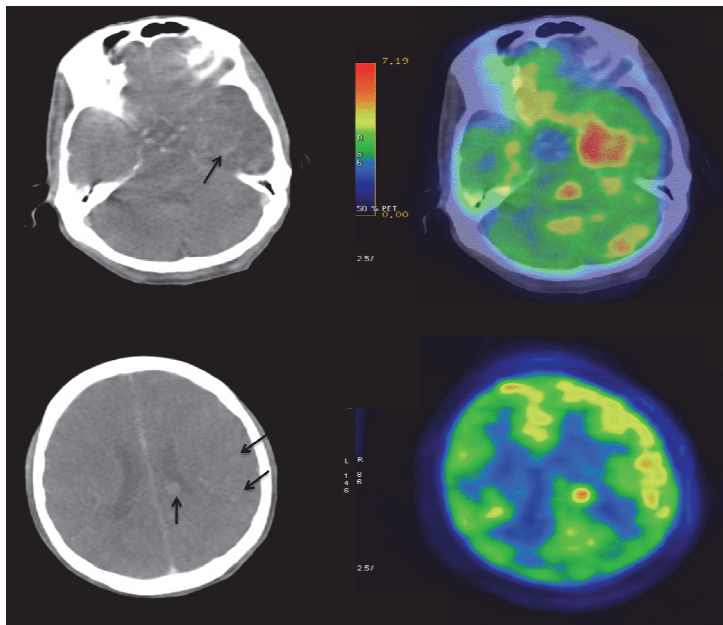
Single phase contrast enhanced PET CT in a 28-year old man demonstrating subtle enhancing intracerebral (black arrows) tuberculosis abscess in the brain.
